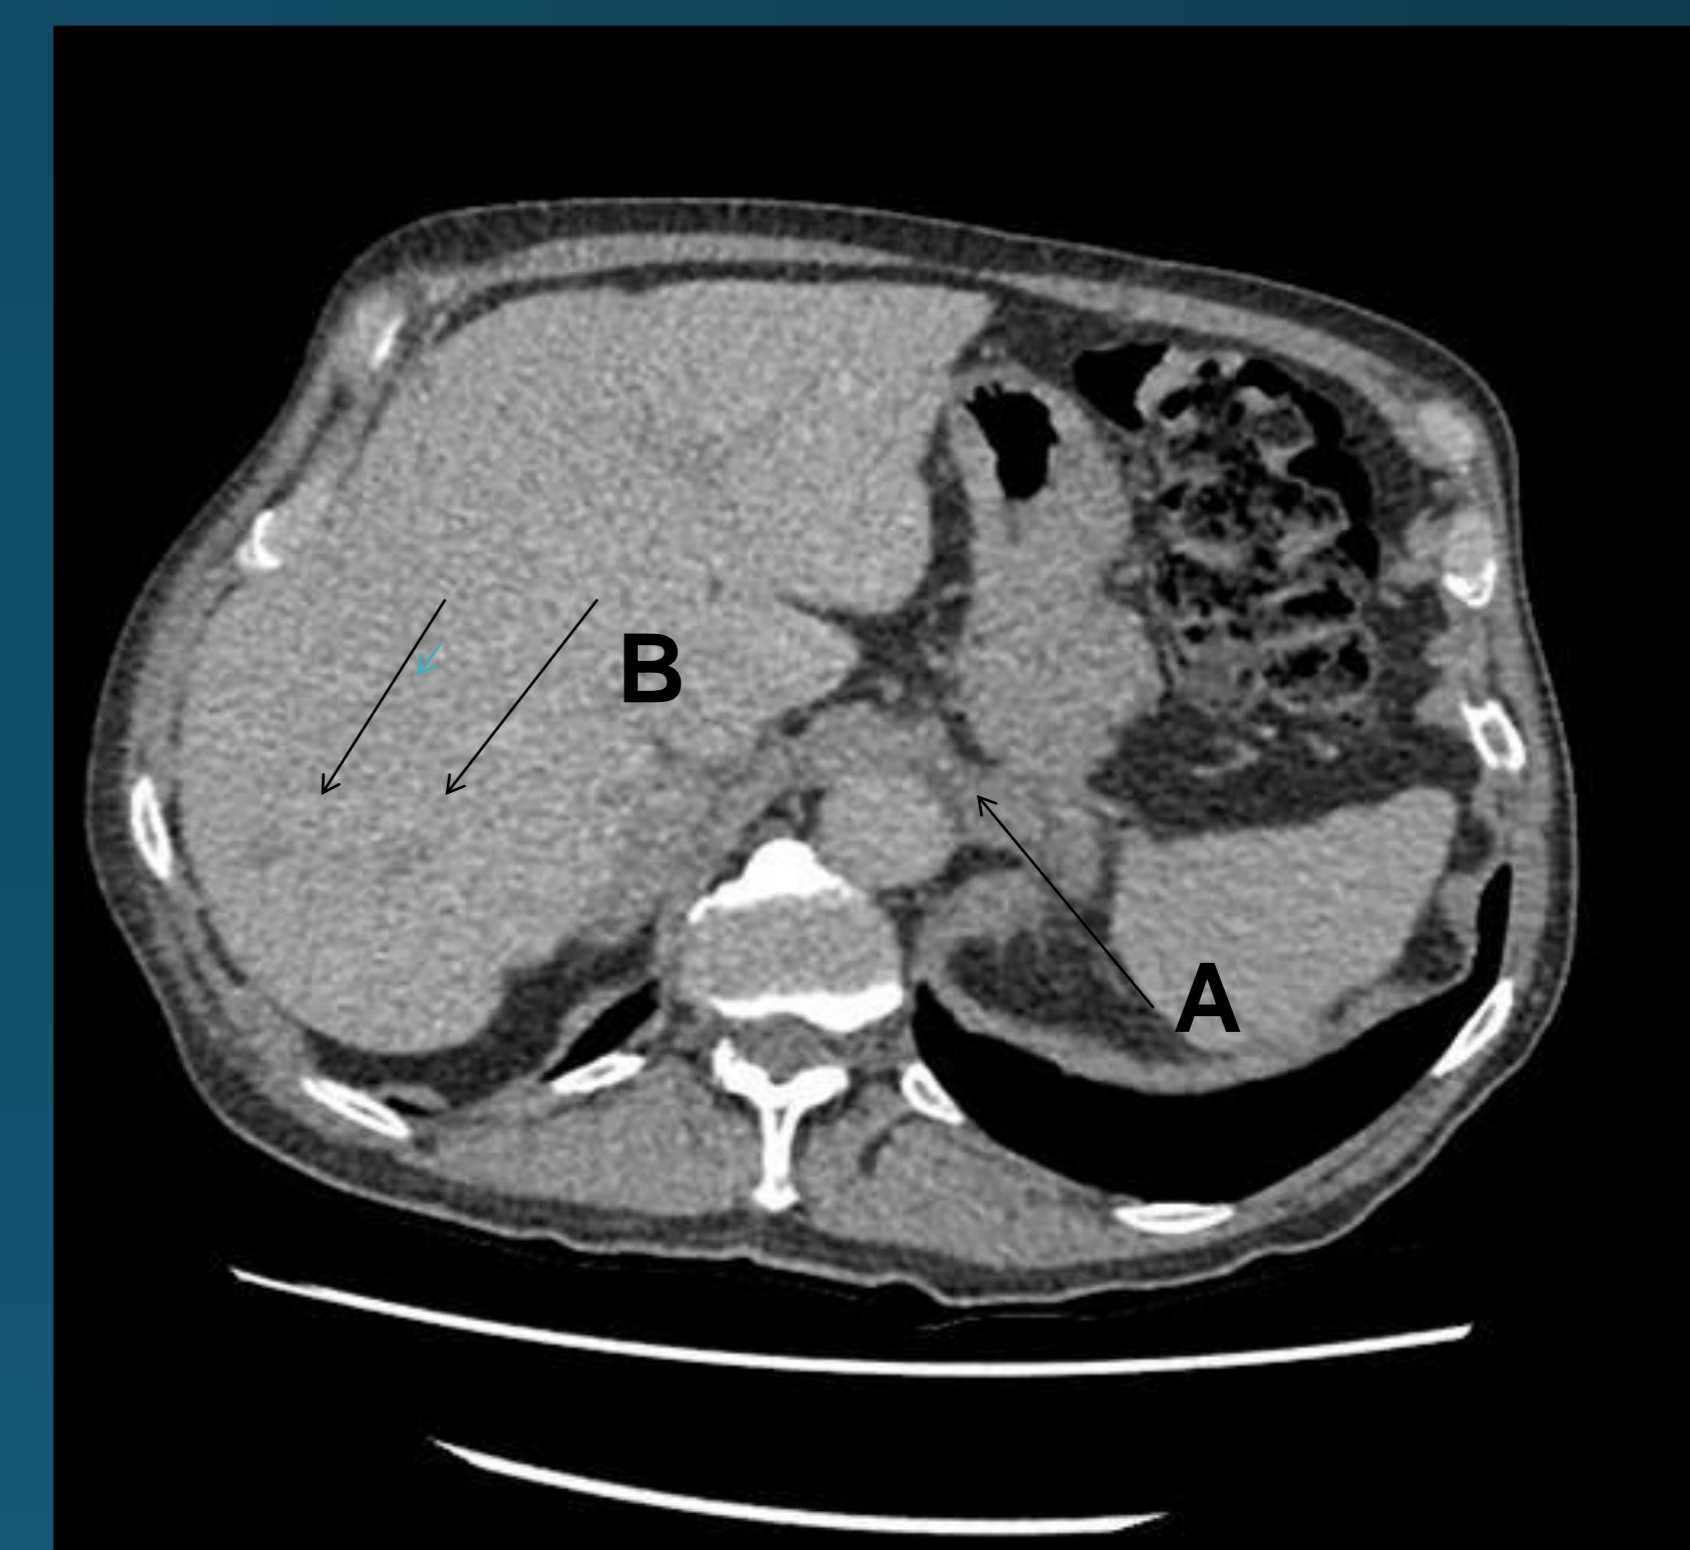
CT scan: para aortic lymph nodes (A) and hepatic metastases (B)
